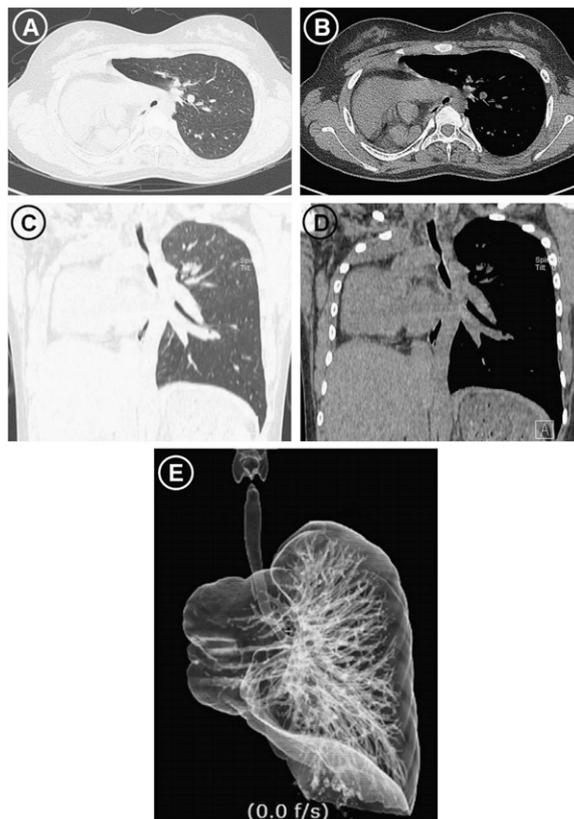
Chest computed tomography (CT) scan and three-dimensional CT bronchogram showed absence of the right main bronchus, right branch of the pulmonary artery, and right lung parenchyma, hyperinflated and enlarged left lung, and deviated heart and main vessels into right thoracic cavity (A–D: CT of chest, E: 3D CT bronchogram).
